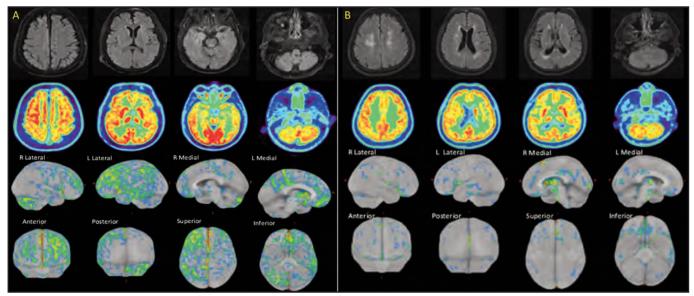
A&B (Corticobasal Degeneration & Vascular Dementia). (3A) T2/FLAIR images (top row) showed an old lacunar infarct in the left internal capsule's genu. Ventricles and subarachnoid spaces were age-appropriate. F-18 FDG PET images (second row) and Z score maps (third and fourth rows) revealed asymmetrical FDG hypometabolism predominantly on the left, affecting the bilateral frontal, parietal, temporal, and posterior cingulate cortices, as well as the thalamus and midbrain. Right cerebellar diaschisis was also noted. (3B) T2/FLAIR images (top row) showed multifocal old infarcts with hemorrhagic components and severe small vessel disease, suggesting vascular dementia. F-18 FDG PET images (second row) and Z score maps (third and fourth rows) revealed FDG hypometabolism in the bilateral frontal cortices and right anterior striatum (caudate head and ventral striatum).
